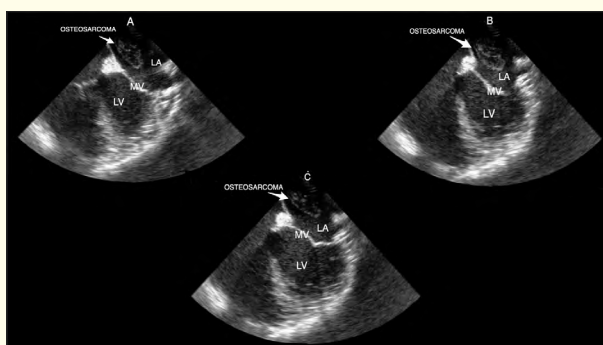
(A-C): Transesophageal Echocardiogram (TEE) images in (A) shows the osteosarcoma in the left atrium (LA) while the mitral valve (MV) is closed in systole; (B) shows a slight movement in the osteosarcoma as the MV opens for diastole; (C) shows the mobility of the osteosarcoma as it has moved further from the MV in systole. LA, Left Atrium; LV, Left Ventricle; MV, Mitral Valve.
